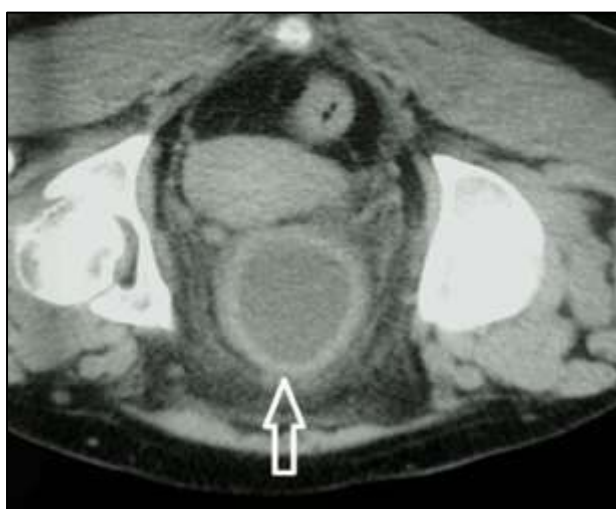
CT scan depicting obliteration of fat plane between uterus and bladder, suggesting possible infiltration.
